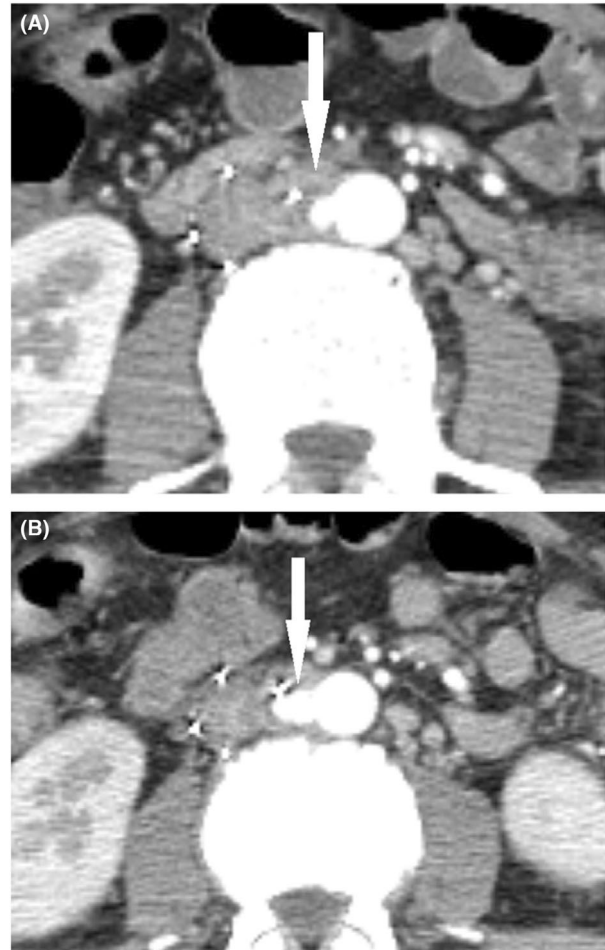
(A) Enhanced computed tomography scan of a 45-year-old man on hospital day 2, indicating an abdominal aortic pseudoaneurysm with an inferior vena cava (IVC) abscess at the site of the IVC filter limb (arrow). (B) Enlargement of the aortic pseudoaneurysm (arrow) evident on hospital day 13.
